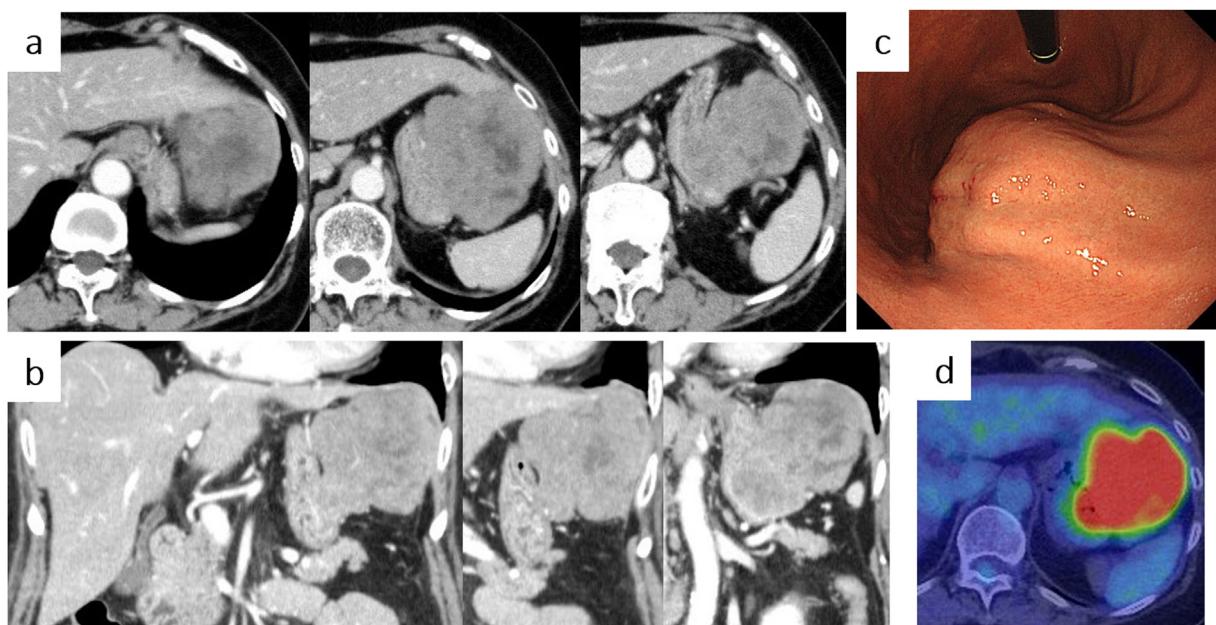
a. Axial image of abdominal CT scan showed a large heterogeneous gastric mass with contrast effect measuring 80 mm in size, arising from the greater curvature of the corpus. b. Coronal image of CT revealed that the mass invaded the left thoracic diaphragm and left hepatic lobe. c. Upper gastrointestinal endoscopy (UGI) detected a well-circumscribed submucosal tumor in the greater curvature. d. 18F-FDG PET/CT revealed intense 18F-FDG accumulation (SUVmax 22.9) in the tumor and no evidence of distant metastasis.
